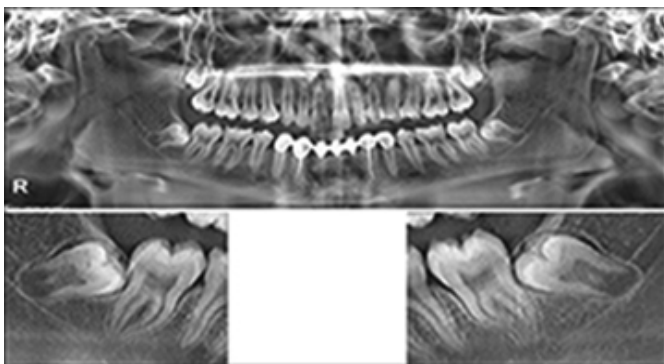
Postoperative panoramic radiograph of the same patient after a year.
